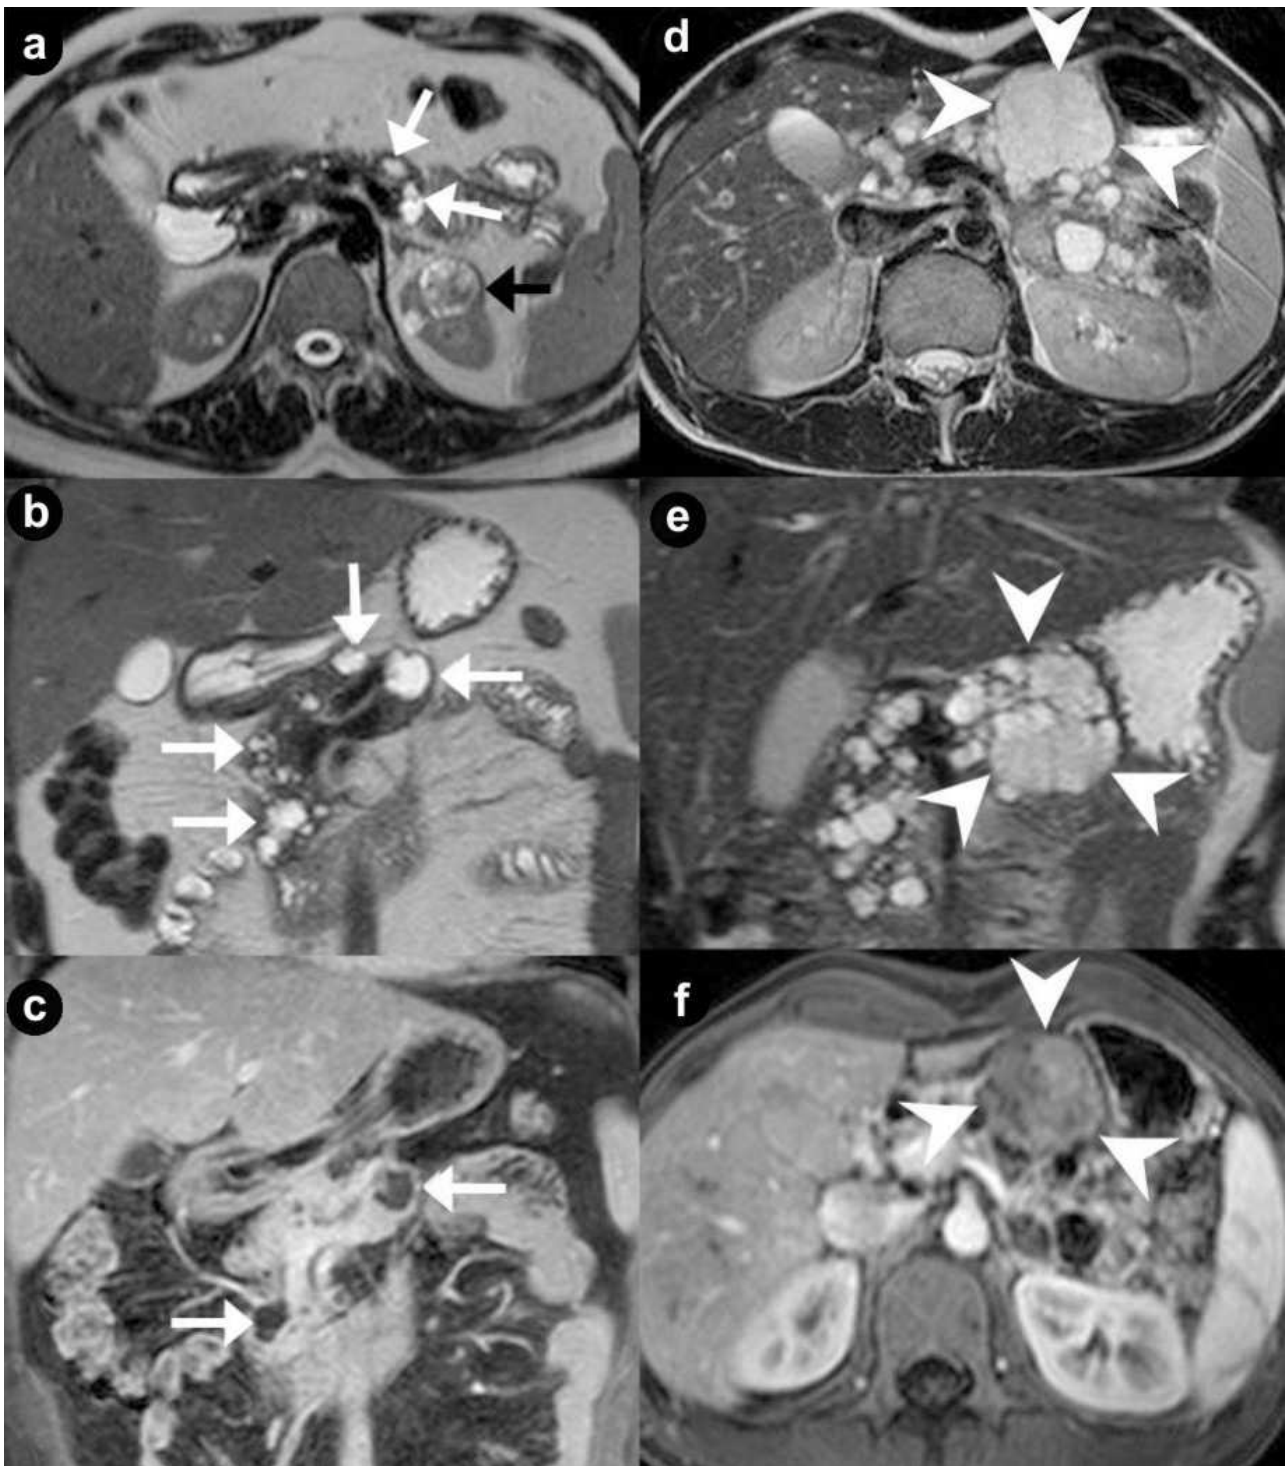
Pancreatic unilocular cysts (a. b. c. Case#1: 35-year-old man with VHL disease). Pancreatic microcystic serous cystadenoma (d. e. f. Case#2: 30-year-old man with VHL disease). Axial (a. d.) and coronal (b. e.) T2-weighted MR images; coronal (c.) and axial (f.) 3D volumetric gradient-echo T1-weighted fat suppressed images after intravenous contrast medium administration during arterial pancreatic phase of contrastographic dynamic study.
